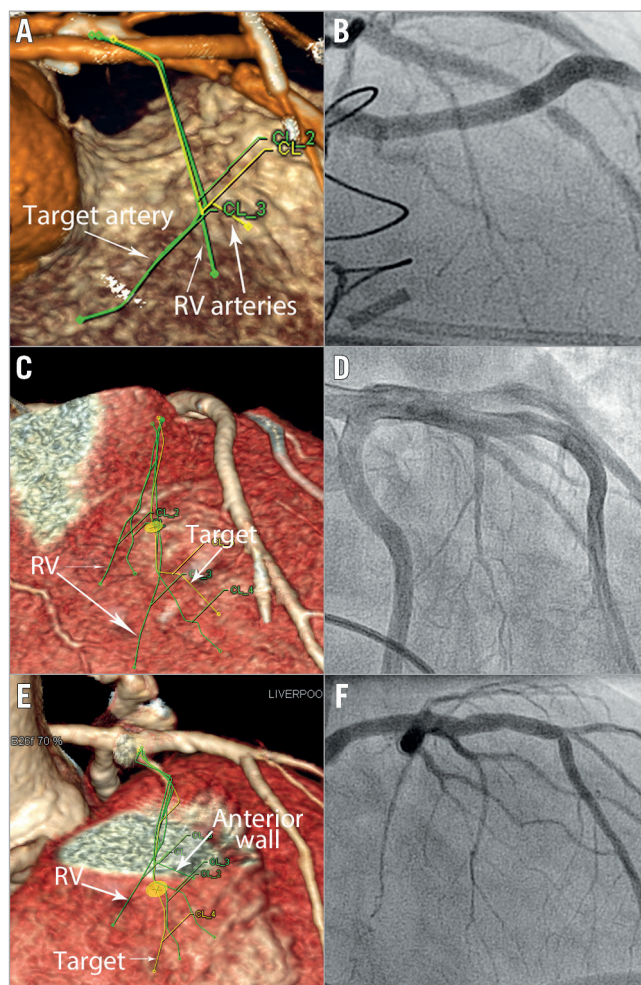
CT angiography with matched invasive angiography projections. A) CT angiogram. The traced septal vessels from 2D images were projected onto the coronary angiogram “map” (Moving image 1). This CT angiogram was rotated to minimise foreshortening and remove overlap (in this example to RAO cranial). The equivalent invasive angiogram projection is shown in panel B. The target artery is identified and only this sub-branch is occluded for alcohol delivery. Further examples are shown in panels C & D and E & F.
